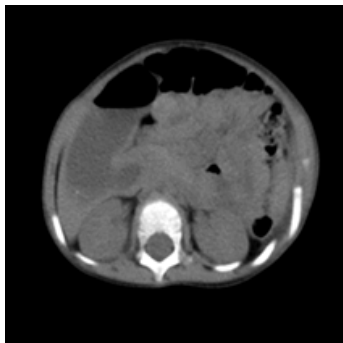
An abdominal CT showed the annular pancreas surrounding segment 2 of the duodenum.
